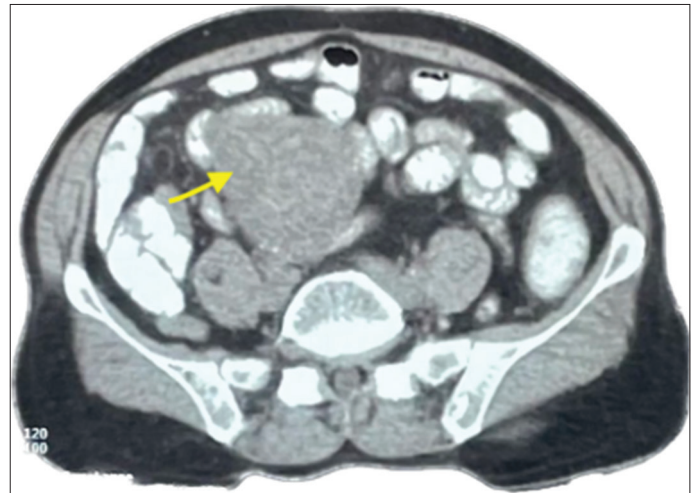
Contrast-enhanced computed tomography abdomen (axial section) showing a complex lobulated mass in relation to the ileum (yellow arrow depicting the mass)
